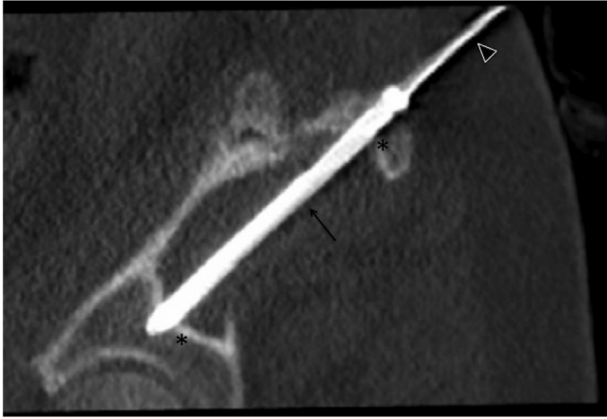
(Patient 1) Sagittal-oblique reformatted computed tomography image shows a 105 mm long \times 6.5 mm wide screw (arrow) placed over a Kirchner guide wire (arrowhead) through the long axis of the lytic cavity (*) embedded in the residual acetabulum without articular disruption despite scant native bone.
